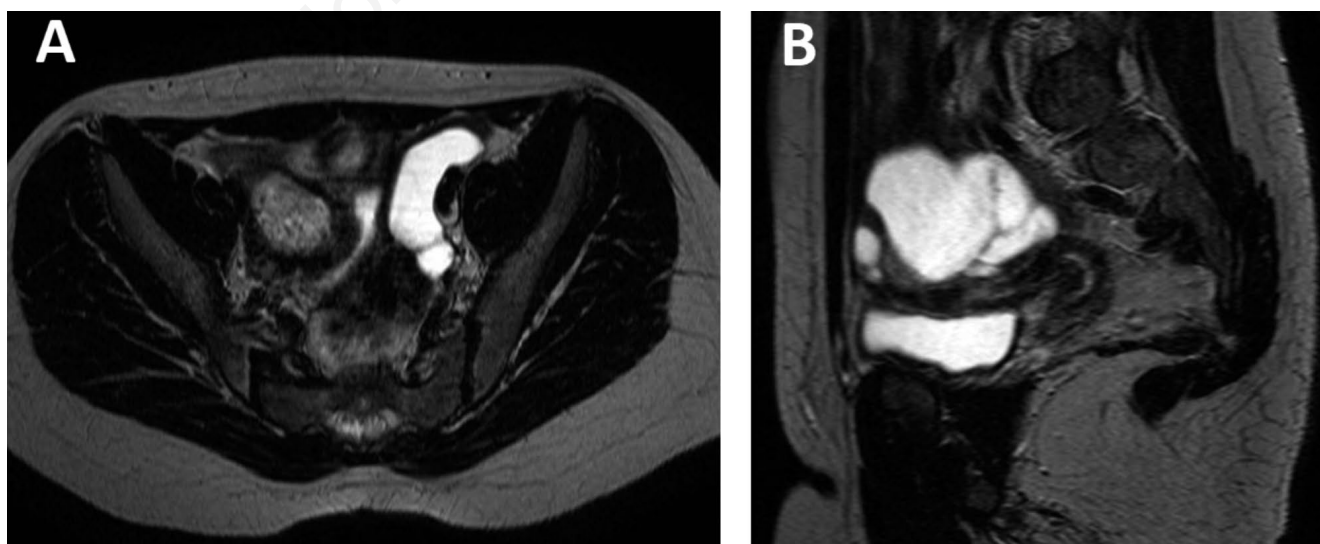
Case 1: A) transverse and B) sagittal section of T2W-MRI scan of left Fallopian tube dilatation.
